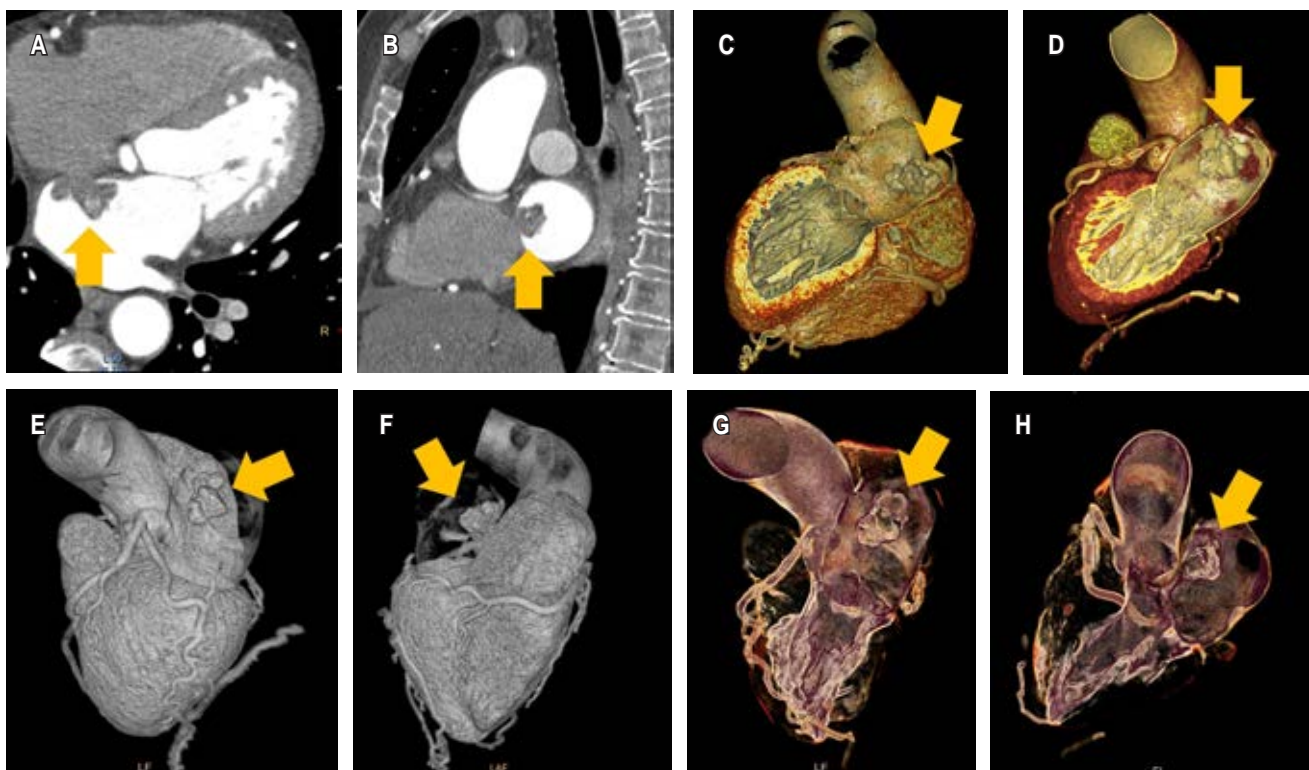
Cardiac computed tomography. A) and B) A mass in the left atrium on contrast-enhanced cardiac computed tomography (arrow). C-H) 3D reconstruction of the left atrial chamber with a mass (arrow).
